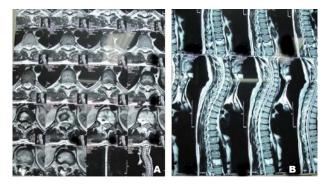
Case 1, (A): Axial T2-weighted MR image of twelfth thoracic spine vertebrae; (B): Sagittal T2-weightedimages of thoracic spine vertebrae.
